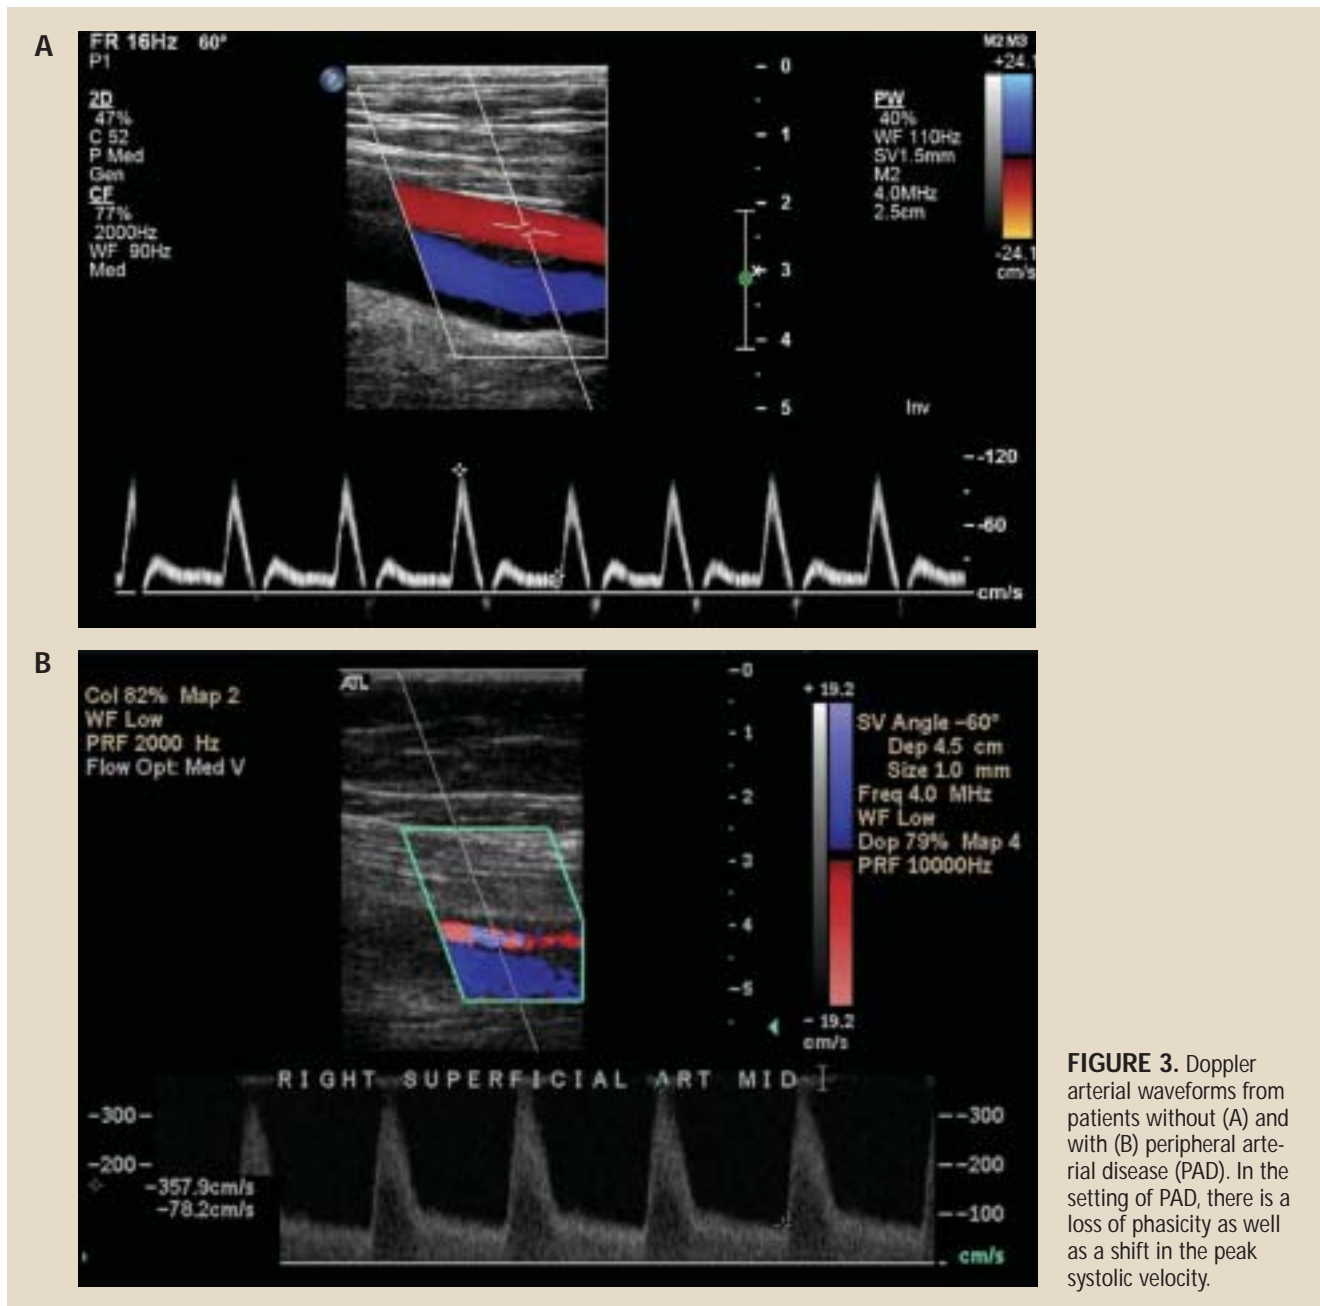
Doppler arterial waveforms from patients without (A) and with (B) peripheral arterial disease (PAD). In the setting of PAD, there is a loss of phasicity as well as a shift in the peak systolic velocity.
